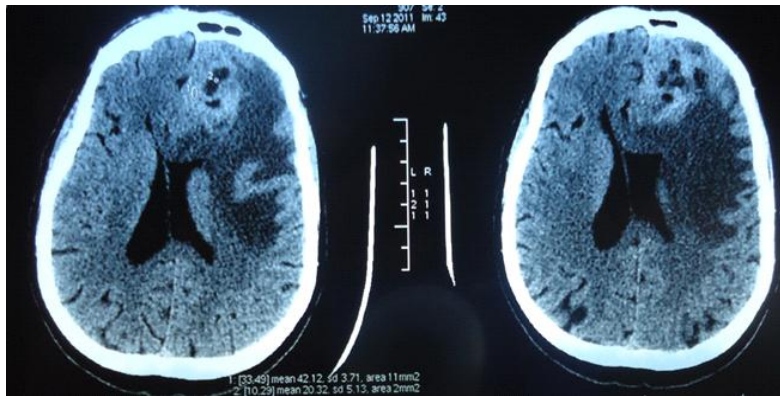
CT image of a left frontal meningioma, compressing the frontal horns of the lateral ventricles
